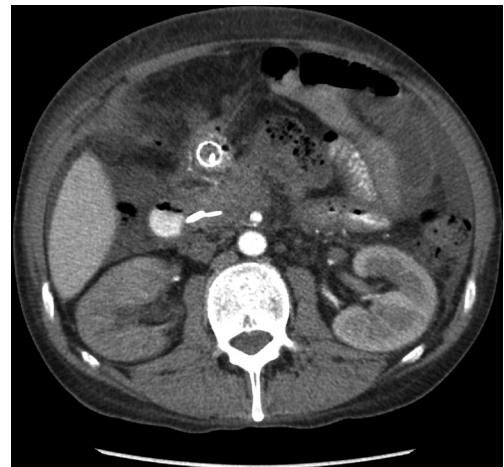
Follow-up computed tomography scan after successful drainage of the WON collection. WON, walled-off necrosis.
